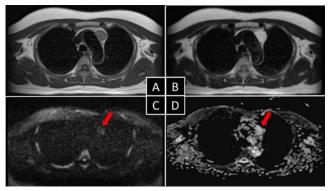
Magnetic resonance imaging (MRI) of the thorax
